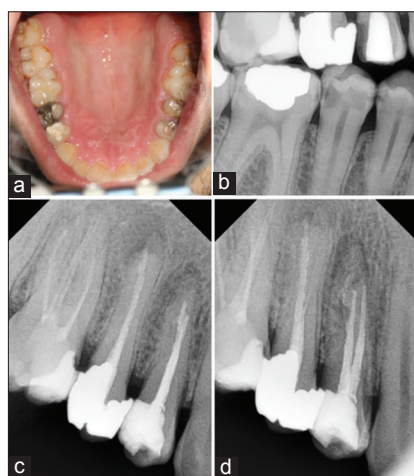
Maxillary right first premolar. (a) Pre-operative photograph of the upper jaw. (b) bitewing radiograph of the right premolar teeth. (c) Straight periapical radiograph of the maxillary right first premolar. (d) Mesial periapical radiograph of the maxillary right first premolar
